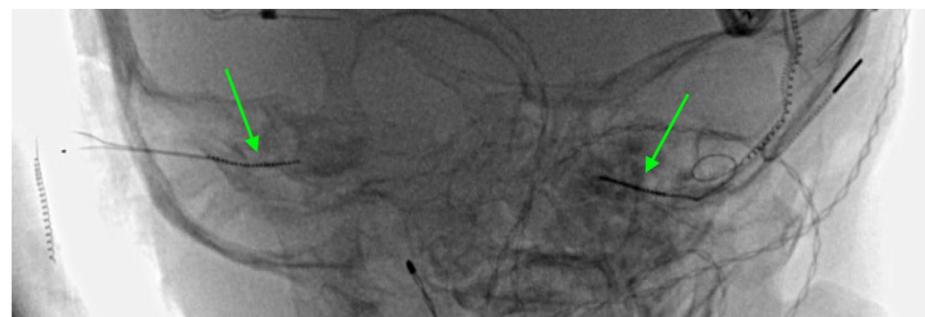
Intraoperative X-Ray showing both electrode arrays in the cochleas (green arrows)
